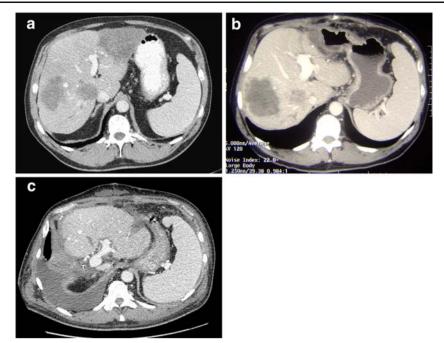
a A computed tomography scan in a 56-year-old patient who developed synchronous bilobar colorectal metastases and was treated by left colectomy and 6-month systemic chemotherapy. b Six
